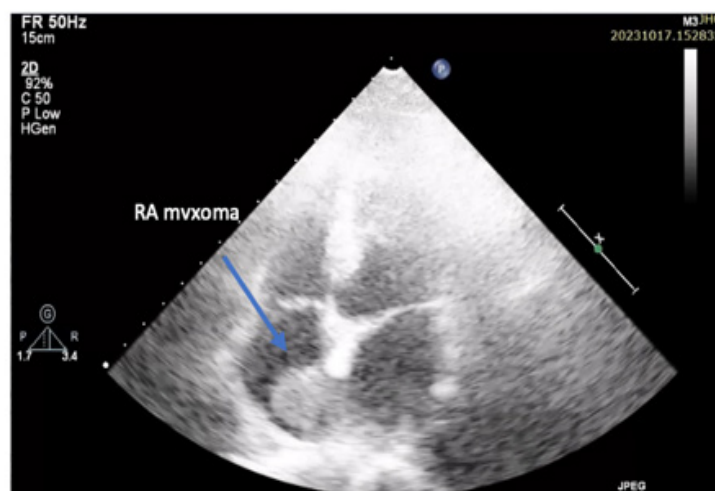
Transthoracic echocardiography of right atrial myxoma.
